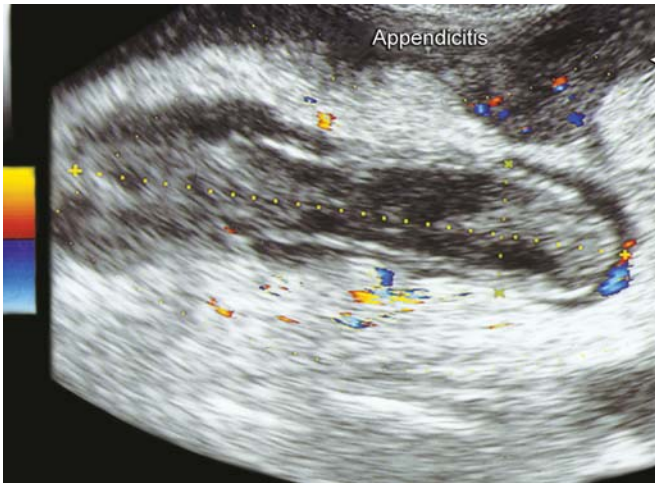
Sign of color Doppler throughout the tube which suggests acute infection
